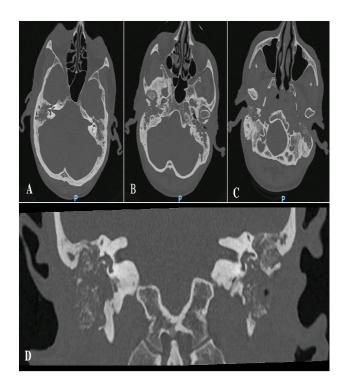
(A-D): CT scan showing a bilateral soft tissue opacification of the middle ear and ear canal and a diffuse temporal bone destruction with bone sequestrum. This bone destruction includes the anterior wall of the ear canal, with an involvement of the temporomandibular joint, the posterior wall of the ear canal in contiguity to the mastoid which is also highly destroyed, the inferior and superior walls of the ear canal and the ossicular chain with no identifiable ossicles. Of notice, also a complete dehiscence and exposure of the facial nerve in both the tympanic and mastoid portions bilaterally, as well as an erosion of the lateral semicircular canal on the right.
